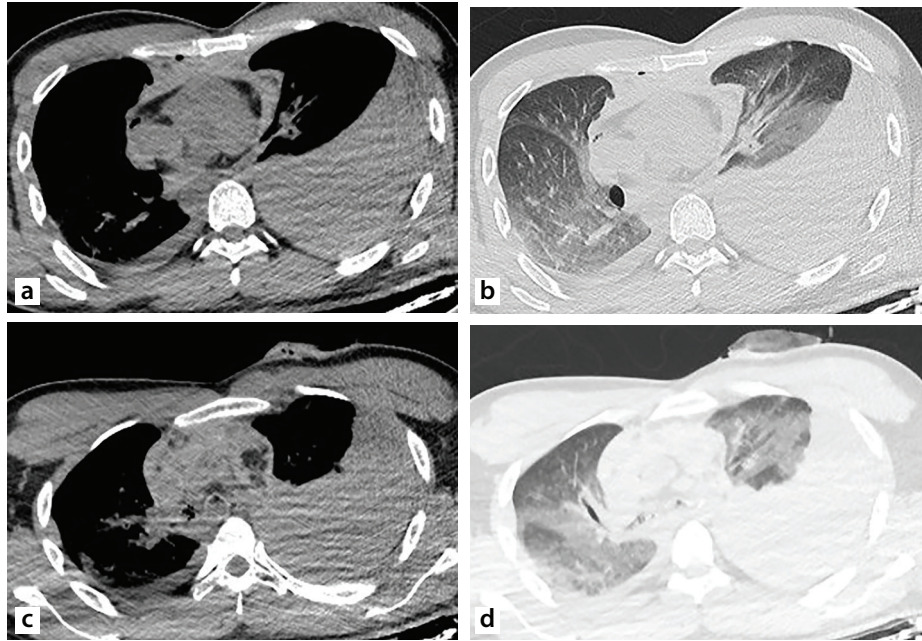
A 24-year-old Syrian man sustained a fatal stab wound to the anterior left chest wall. Computed tomography scans showed an anterior mediastinal hematoma (a), bilateral hemothorax, and a defect in the anterior chest wall (b). Retrosternal hematoma (c) and millimetric pneumothorax (d) were also noted.
